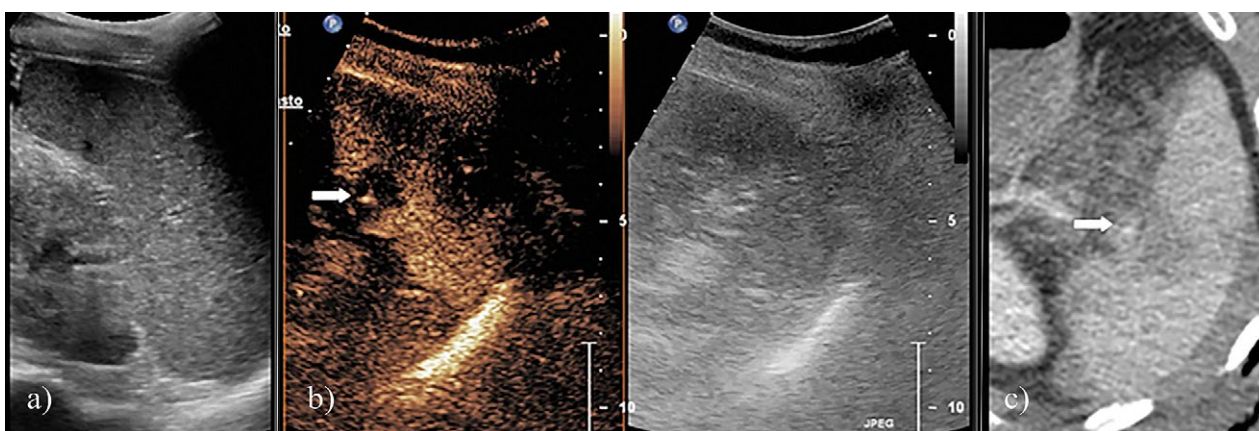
A 82-year-old woman with AAST-SIS grade II splenic injury. Seven days after blunt abdominal trauma conventional US (a) did not evidence the splenic lesions. CEUS showed the splenic injury and a small pseudoaneurysm (arrow) was suspected (b). CT (c) did not confirm the latter and demonstrated that it was a small para-hilar arterial vessel (arrow).
